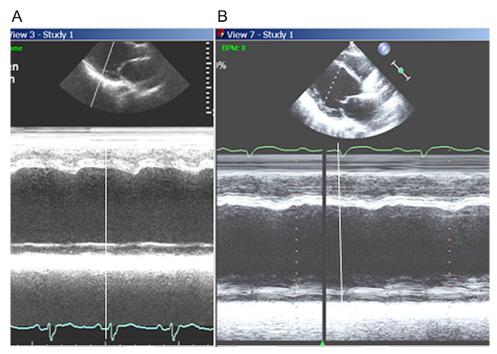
M-mode recordings before (A) and after (B) resynchronization of a patient with a dilated, poorly functioning left ventricle and no echocardiographic findings of LBBB. There is no improvement.
